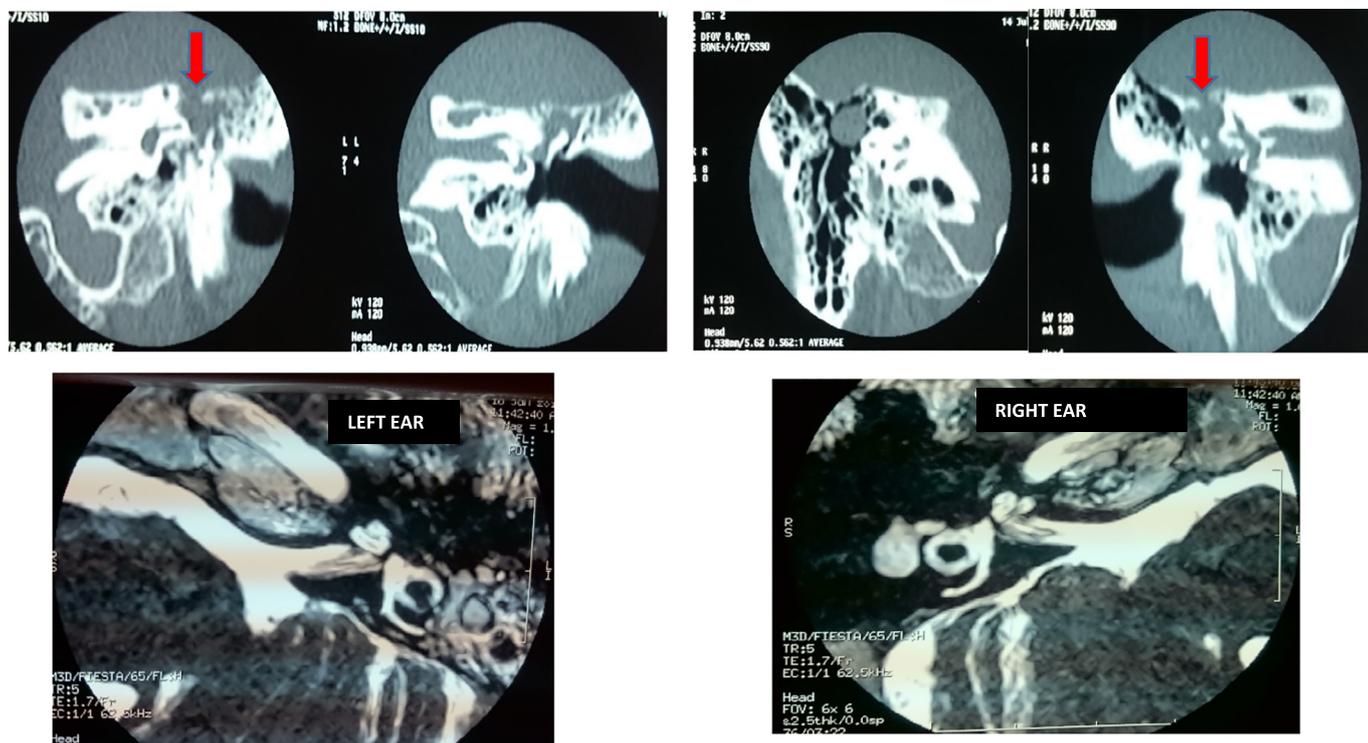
Coronal CT and axial T2 weighted MRI showing: bilateral mastoid tegmen defect (arrow). Right ear: pediculated meningoencephalocele Left ear: mastoid effusion.
